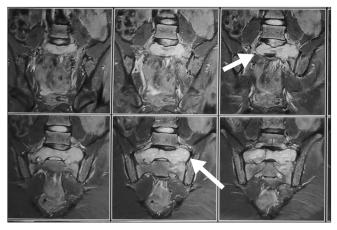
T2 weighted sagittal magnetic resonance imaging scan showing hyperintense lesion in S1 vertebral body expanding into the ala of sacrum (marked with arrow in figure).
